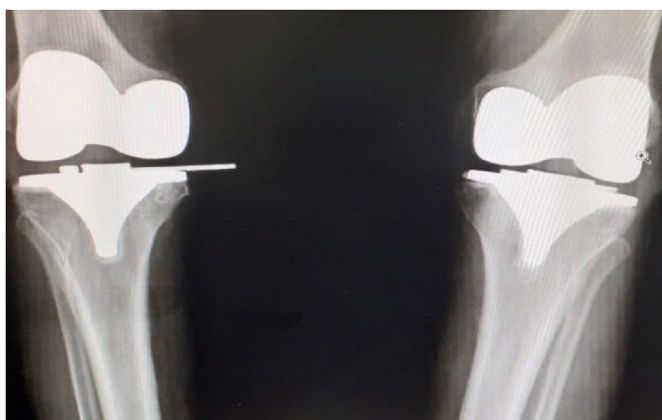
X-rays showing disengagement of locking pin of right knee.
